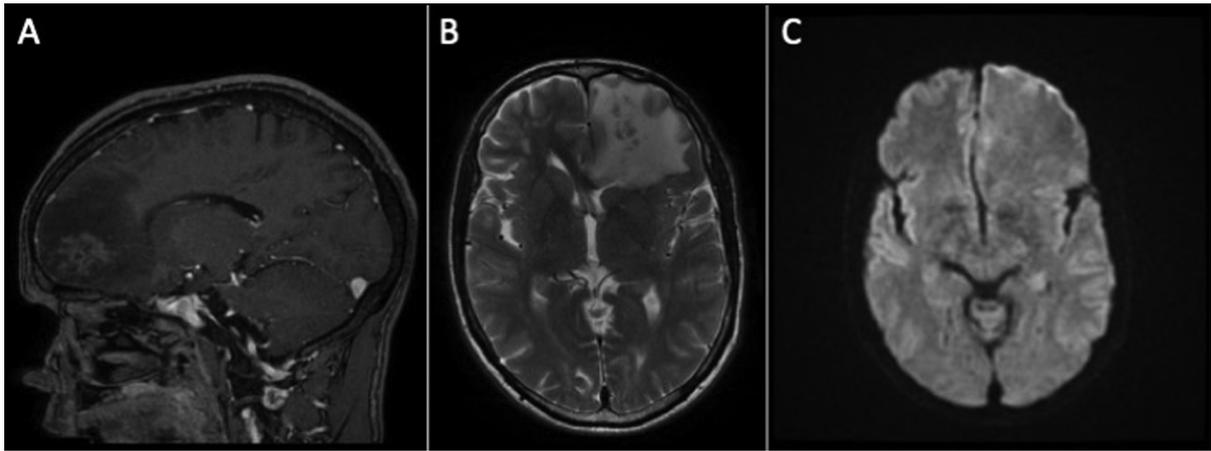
Brain magnetic resonance imaging (MRI) of the case 1. (A) T1-weighted MRI with gadolinium. Note the heterogeneous contrast enhancement. (B) T2-weighted MRI shows heterogeneous lesion with intense perilesional edema. (C) Diffusion-weighted imaging MRI showing absence of restriction on diffusion.
